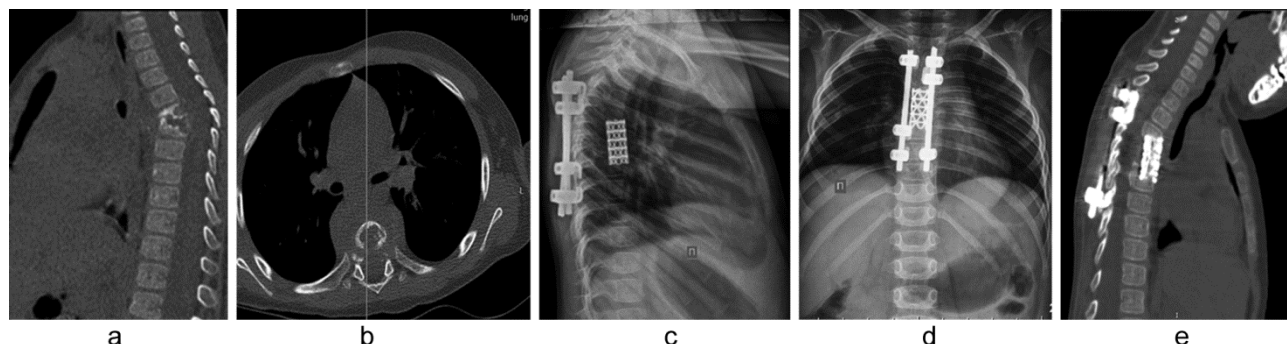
Patient M. aged 2 years 11 months: CT (a and b) before the surgery, kyphotic deformation of Th4-8 41°. X-rays (c and d) after surgery of Th4-8 (anterior interbody fusion using titanium mesh with an auto-bone, posterior instrumental fixation of Th3-9 with a multi-support system of eight hooks). Thoracic CT eight months after surgery (e). Formation of the block inside the mesh is estimated at 4 points (no area of resorption with contact associated with reactive contact sclerosis)
